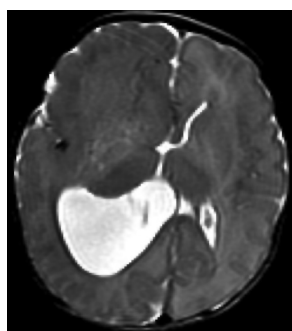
Hemimegalencephaly: neonatal axial T2 MRI shows larger right hemisphere with unilateral ventriculomegaly and abnormal cortication.
